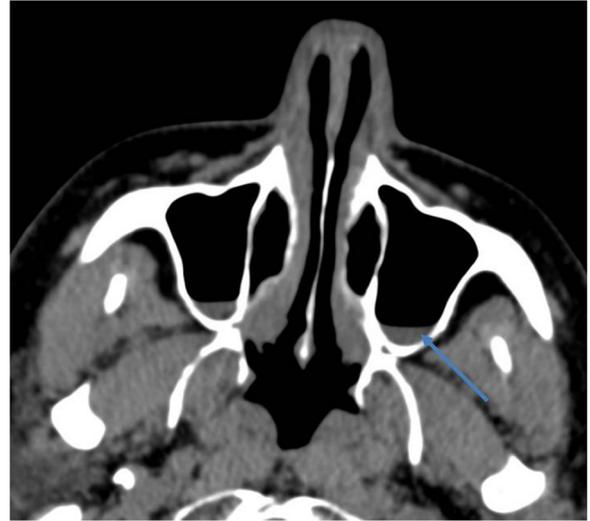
Unenhanced computed tomographic image of the head. There is a fluid level in the maxillary sinuses, with fluid-compatible density (11 Hounsfield units) (arrow). This finding confirms the presence of damage to the cribriform plate.
